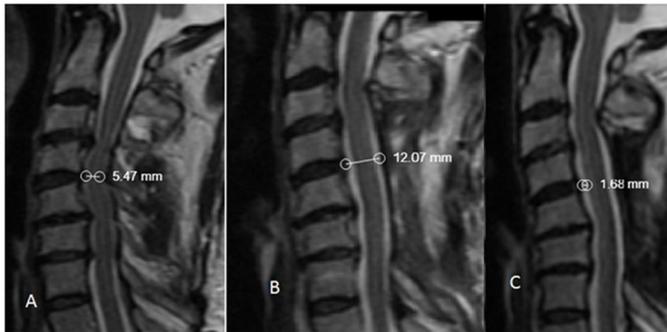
A) Narrowest canal diameter measurement in sagittal T2 MRI examination. B) Measurement of spinal canal diameter in postoperative sagittal T2 MRI examination. C) Measurement of the epidural distance formed in the postoperative sagittal T2 MRI examination.
